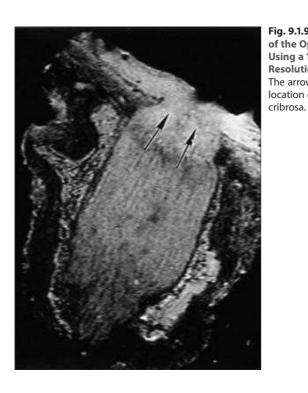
MRI "Section" of the Optic Nerve Seen Using a 12Tesla Ultrahigh Resolution MRI Scan.
